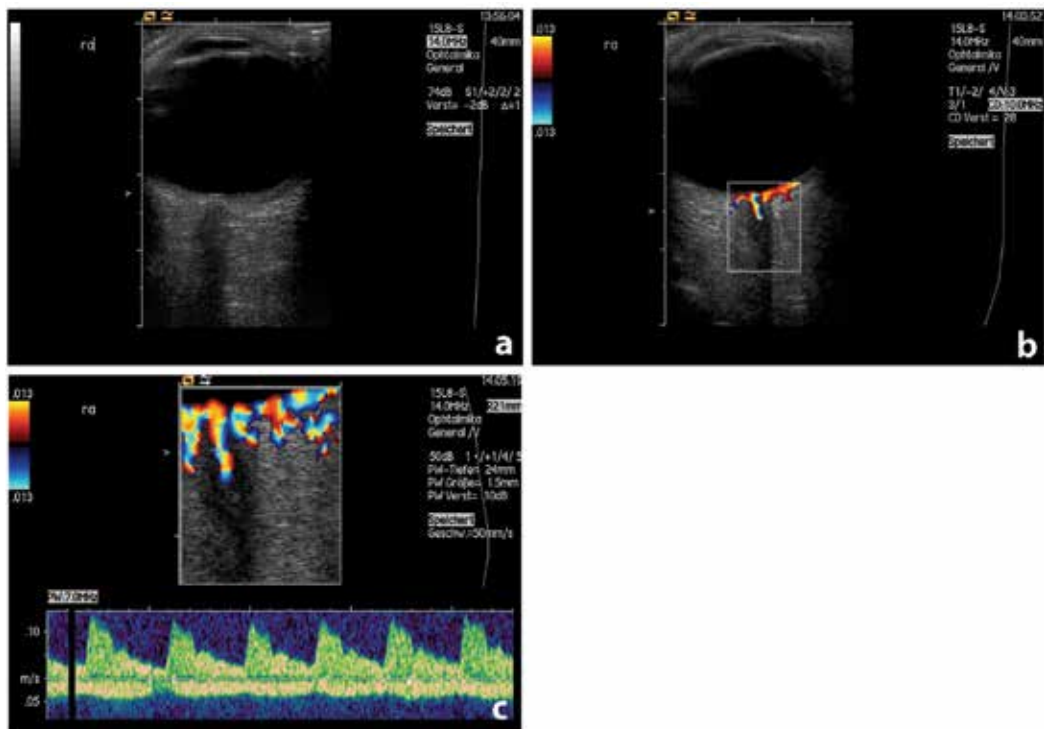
Normal retrobulbar findings using high-resolution ultrasound in B-mode, Color-mode and spectral Doppler: B-mode: (a) The optic nerve presents as a hypoechoic structure beyond the retina and the optic disc (b) Color-coded Duplex mode: central retinal artery (CRA) accompanying the optic nerve; section of retinal vessels from the posterior ciliary artery and the Circle of Zinn and Haller (c) Spectral-Doppler with Duplex-mode: normal spectrum of the CRA with peak-systolic velocity of 10.3 ± 2.1 cm/s and the underlying central retinal vein with peak-systolic velocity of 2.9 ± 0.73 cm/s (see also Table 2)
